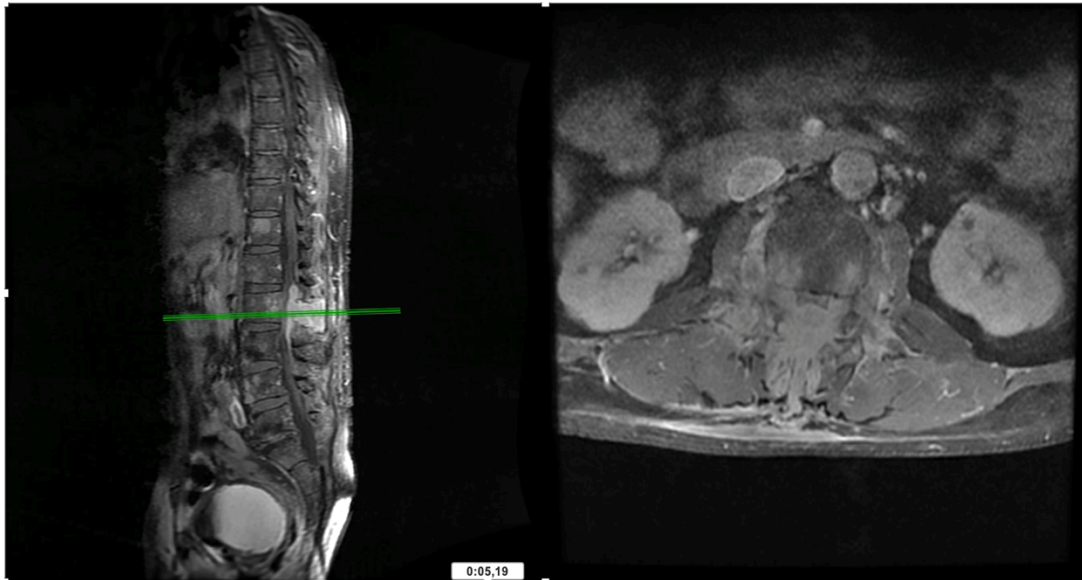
Whole spine MRI*
